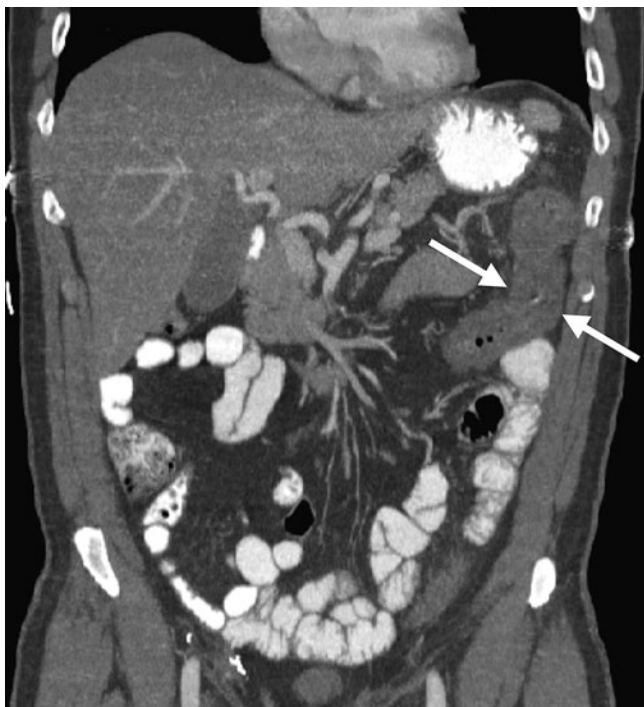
Ischemic colitis. Coronal reformat computed tomography (CT) reveals mural thickening of the splenic flexure of the colon (arrows), the most common location for colonic ischemia
